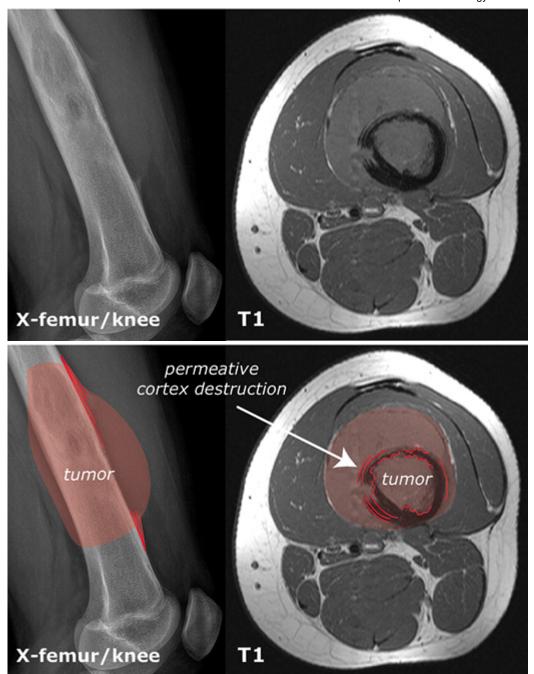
X-ray of left upper leg/left knee: lytic lesion in the femur with multilayered periosteal reaction and soft tissue mass (PA diagnosis: osteosarcoma). The T1 weighted image clearly visualizes the permeative cortex destruction and the breakthrough into soft tissues. Note also the abnormal low signal intensity of the bone marrow (fat has been replaced by tumor).
